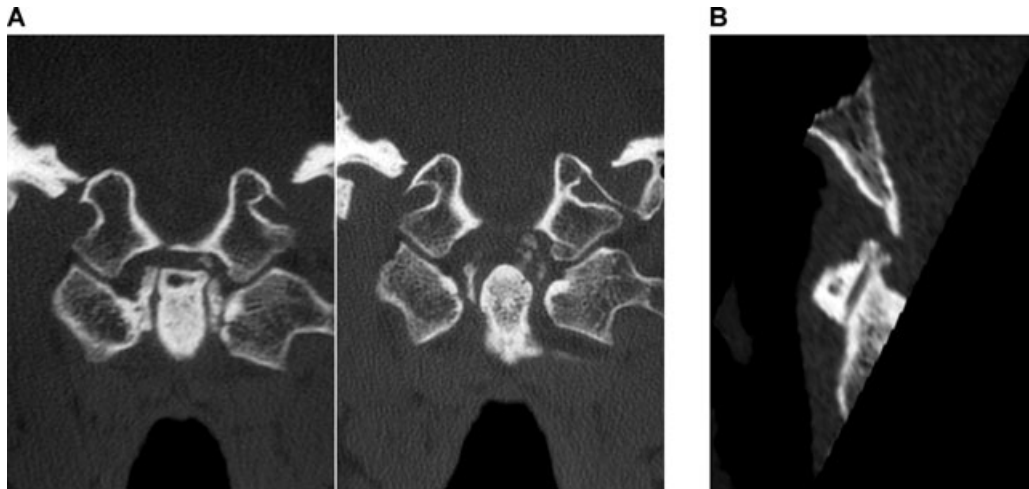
CT scans of the temporal bones of an asymptomatic 73-year-old woman (follow-up of right mastoidectomy for treatment of cholesteatoma). Direct coronal CT scans (A) and a reformatted sagittal image (B) show the typical “crowned” appearance of the odontoid process and severe degenerative changes of the median atlanto-axial joint.
